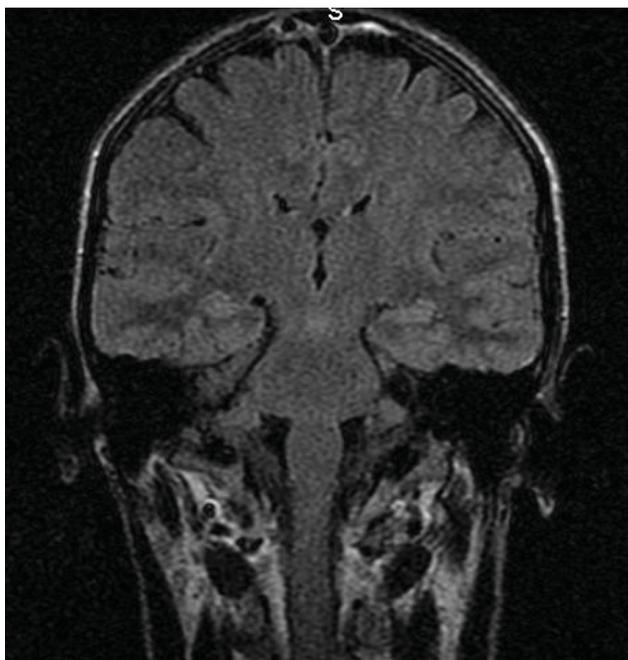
Coronal FLAIR MRI section; normal brain aspect
